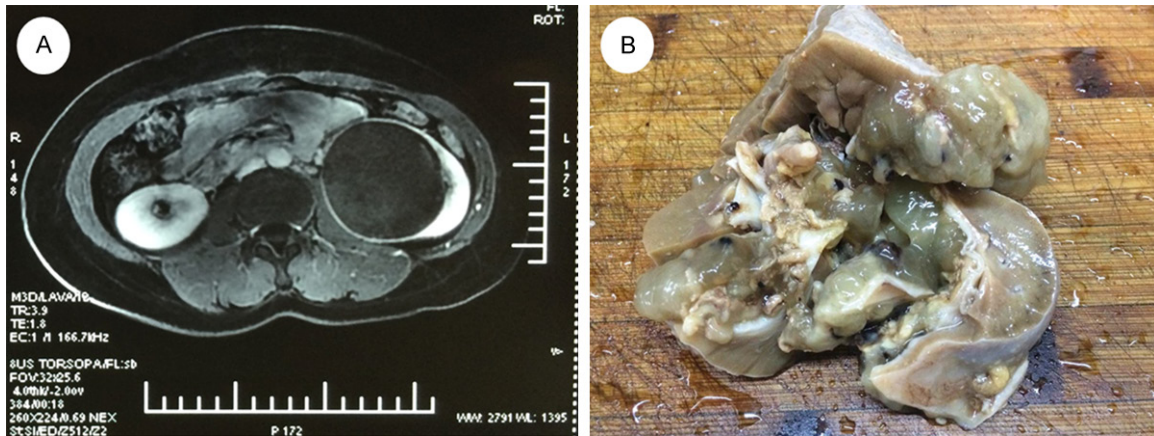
A. Computed tomography (CT), showing a large cyst arising from the left kidney. B. The cyst was filled with abundant yellowish mucinous or gelatinous material.
